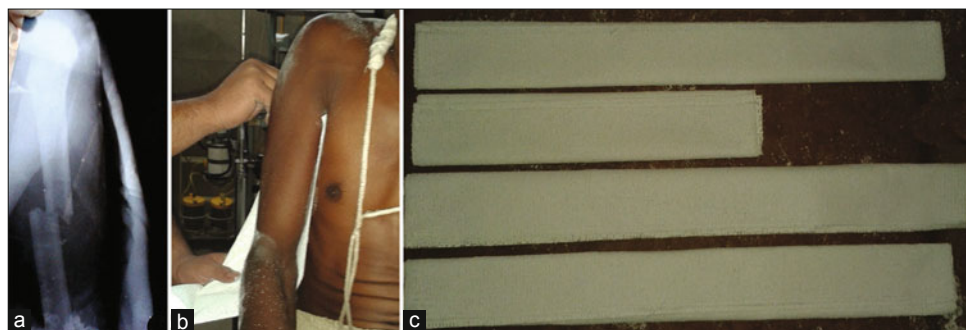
(a) X-ray of left arm with shoulder joint showing fracture of left humeral shaft (b) Clinical photograph showing measurements of plaster of paris cast strip (medial) on the sound side (c) Longitudinal triple folding of 15 cm plaster bandage for lateral, medial, posterior and anterior aspects
